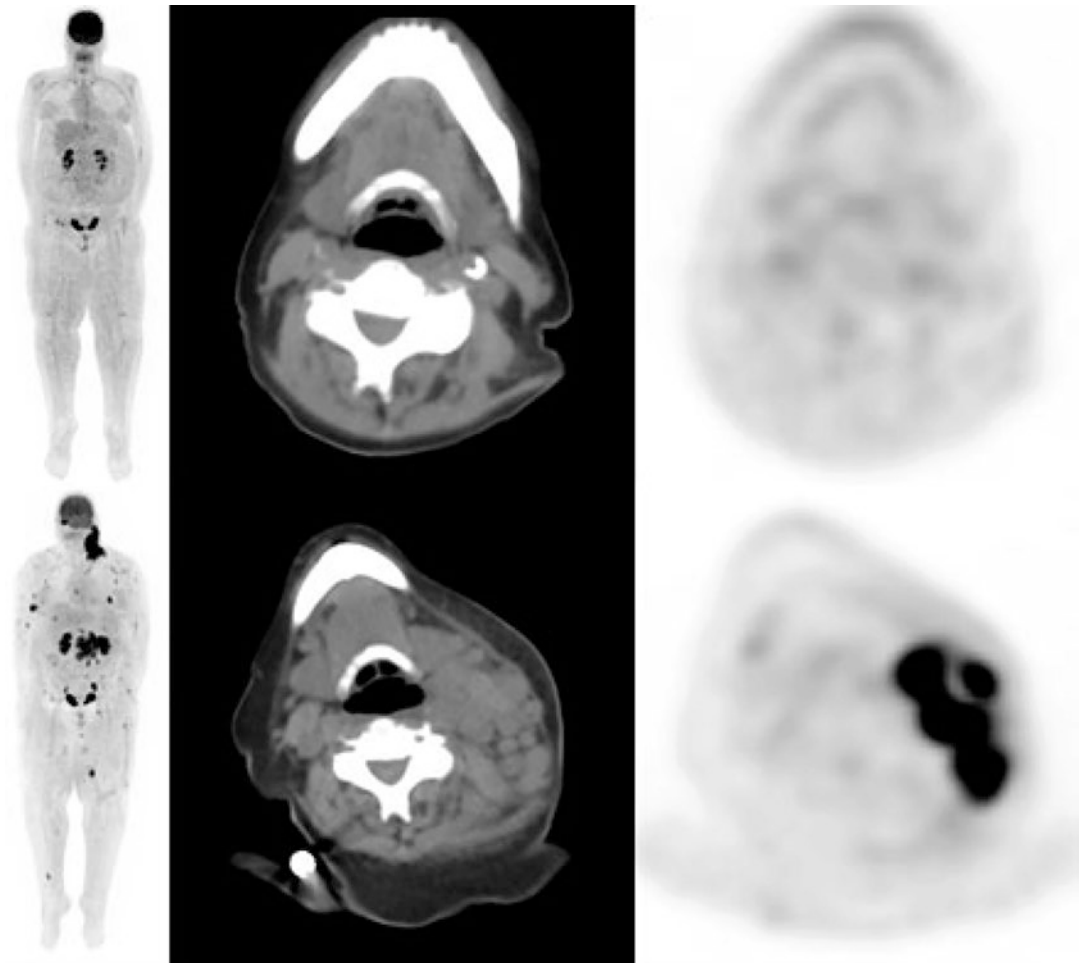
A 58-year-old female with a history of lymphoma. FDG PET/CT images demonstrate widespread lymphoma predominantly involving the left cervical
